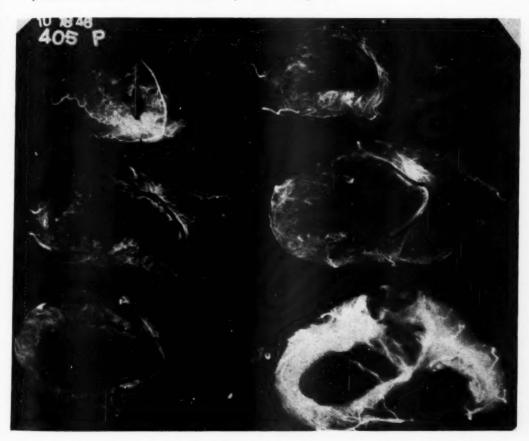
Roentgenogram of the injected heart in Case 75, showing recent septal infarct in solid lines and old, healed posterior infarct in broken lines.
